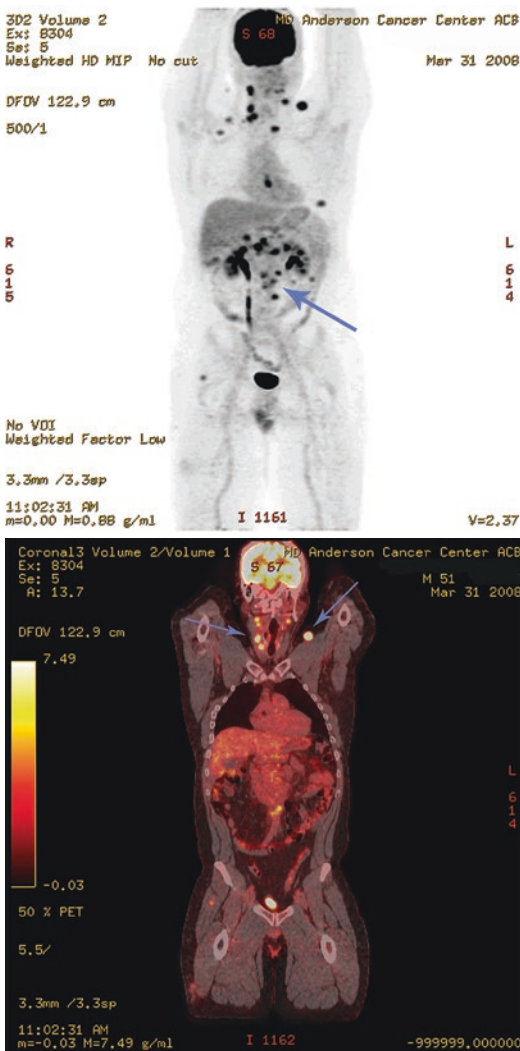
Top:* Maximum intensity projection reconstructed PET image. *Arrow,* one of several abdominal nodal metastases. *Bottom:* Fused PET/CT images, coronal plane through the clavicular heads and pubic symphysis. *Arrows* indicate the patient's palpable left supraclavicular subcutaneous metastasis, as well as unsuspected right neck nodal metastases
